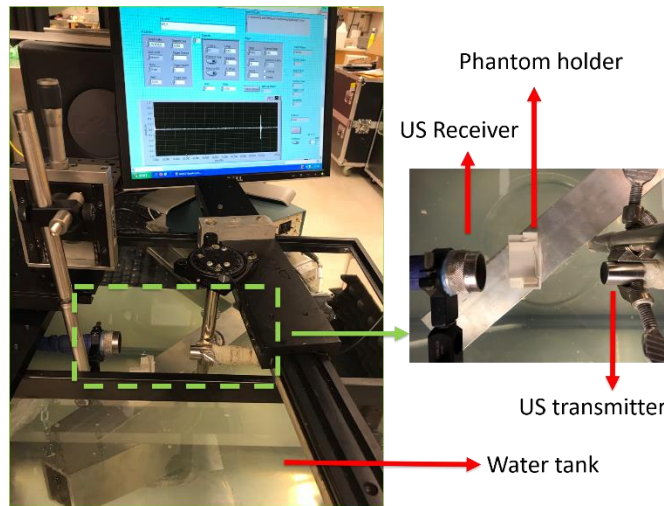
The setup used to measure the ultrasound attenuation coefficient
